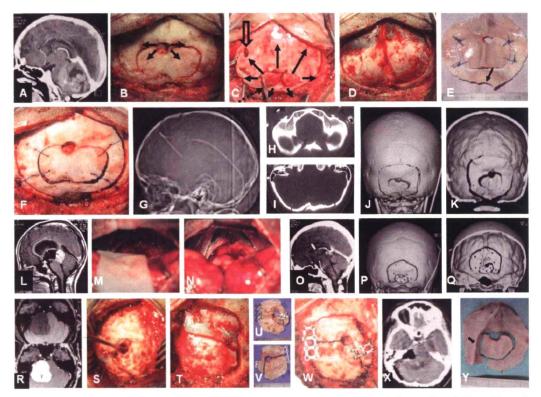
Surgical technique. Cases 3 (A,B, D to G), 11 (C), 6 (H to K), 10 (L to Q), 16 (R to X) and 4 (Y); the patient with a medulloblastoma by cranial computed tomography (CT) (A) suboccipital concentric craniotomy, medial approach, initial burr-hole inferior to inion and epidural dissection (arrows) for initial craniotomy (B), follow with new epidural-venous sinus dissection ( $black\ arrows$ ), look the venous sinus separating ( $open\ arrow$ ) with use of dissector through the initial craniotomy ( $dotted\ arrow$ ) (C), and cut the complete craniotomy (D) without venous sinus injury; internal cranial view of bone flap with foramen magnum opening (arrow) (E), fixed the bone flap (F), in neuroimaging using CT with reconstruction
